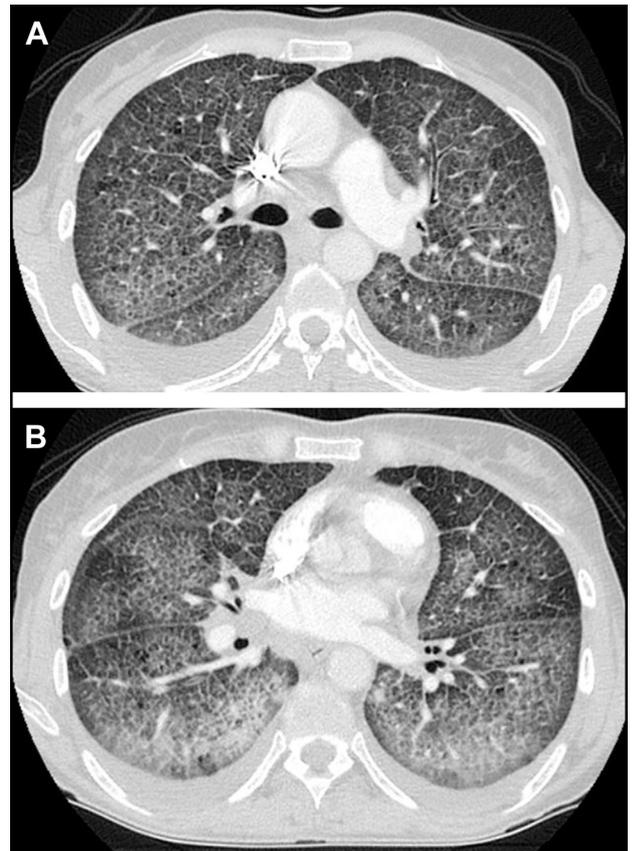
The patient had computed tomography (CT) of the chest. A, Increased reticular markings were more visible on a CT scan. B, An alveolar filling pattern was combined with reticular prominence.
